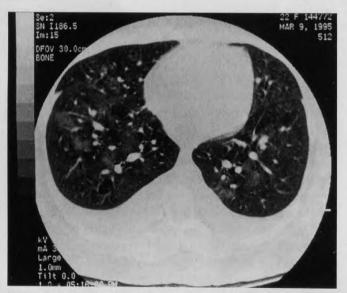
Computed tomographic scan of the chest with contrast showing diffuse patchy interstitial infiltrates and small bilateral pleural effusions.
